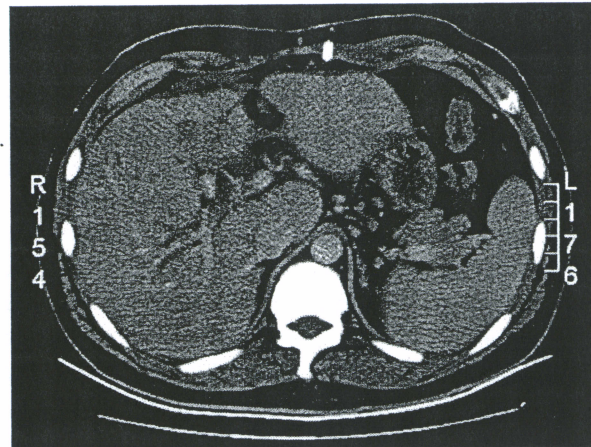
Abdominal computed tomography scan after colistin therapy showing persistent dilated right intrahepatic ducts, with no evidence of the abscess in the intraperitoneal cavity.
